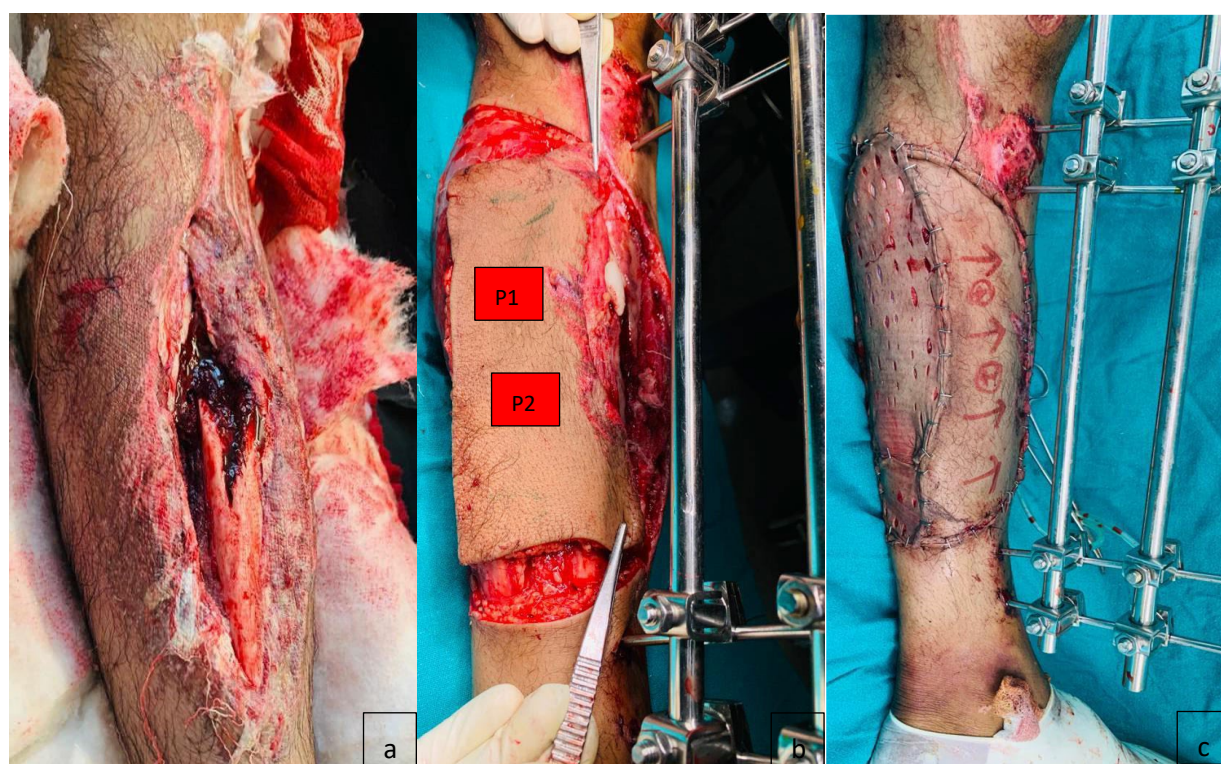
Clinical case 5. (a) Gustilo IIIB defect with fractured tibia, (b) External fixator applied, after debridement, resulting defect measured 16 X 6 cm, from medial side of wound the perforators dopplered (P1, P2) and marked Type IIB Keystone flap designed and elevated for reconstruction, (c) Immediate postoperative result
